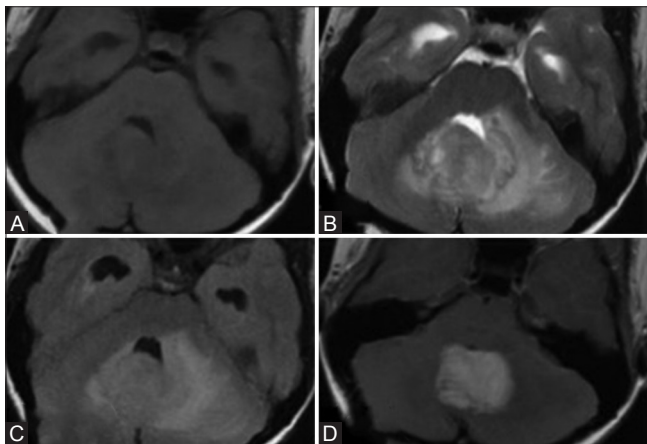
(A-D): History – 13-year-old immunocompetent girl presented with a history of headache associated with nausea and vomiting for 3 months. MRI showed a midline posterior fossa lesion that involved the fourth ventricle which was isointense on T1 W (A), hypo intense on T2 W (B) images, hyper intense on FLAIR (C) with homogenous enhancement on post-contrast study (D). Diffusion and advanced sequences were not done because of the patient's inability to hold still
